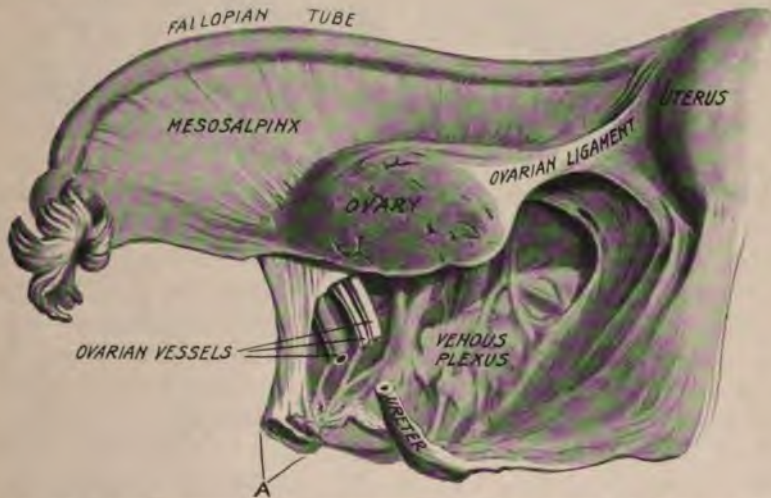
THE POSTERIOR ASPECT OF THE BROAD LIGAMENT. A. Infundibulo-pelvic fold (*ligamentum suspensorium ovarii*) (Charing Cross Hospital Museum).
